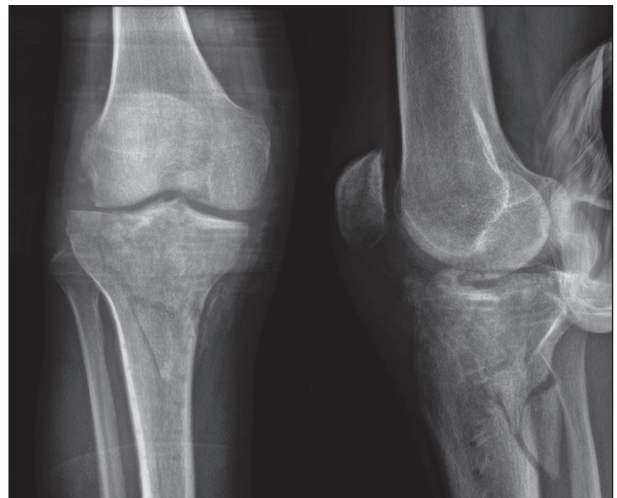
X-rays after removal of plate and screws.
